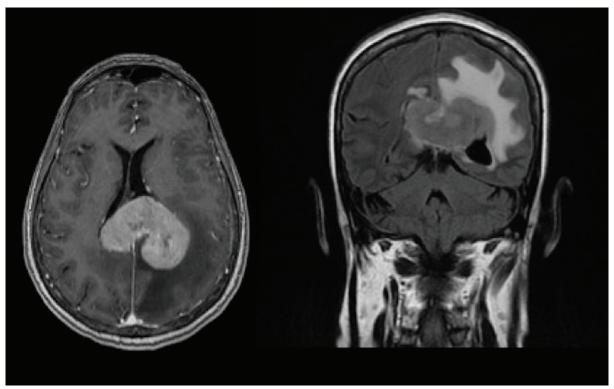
T1 Magnetic resonance imaging of the brain of patient 1 showing cerebral lymphoma infiltration in axial and coronal view of infiltrative lesion in splenium of corpus callosum with the bulk of the lesion in the left side of the midline.
